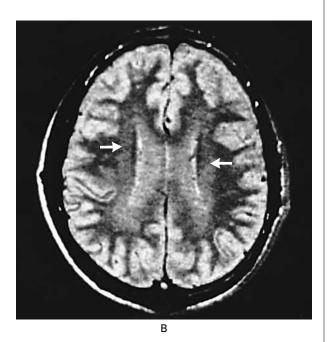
MRI Features of Toxic Leukoencephalopathy.
